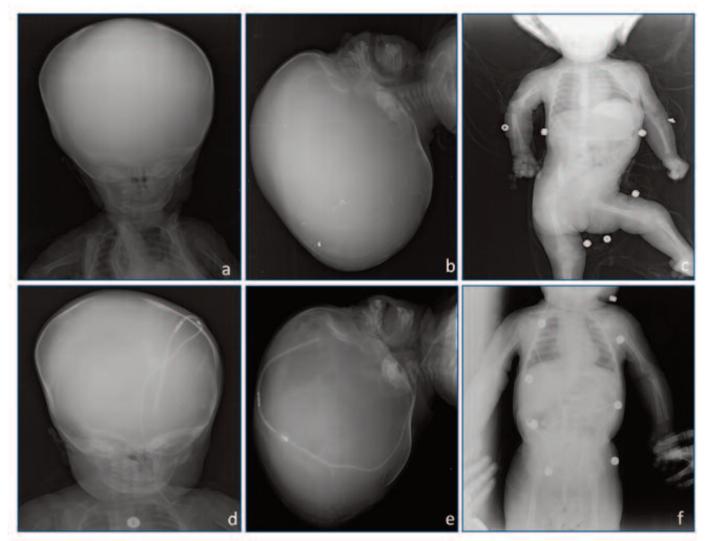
Preoperative (a, b, c) and postoperative (d, e, f) x-rays images of ventriculoperitoneal shunt.
